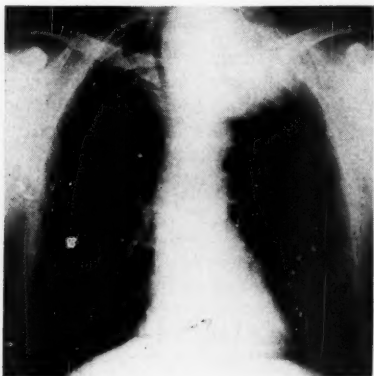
Preoperative roentgenogram.
